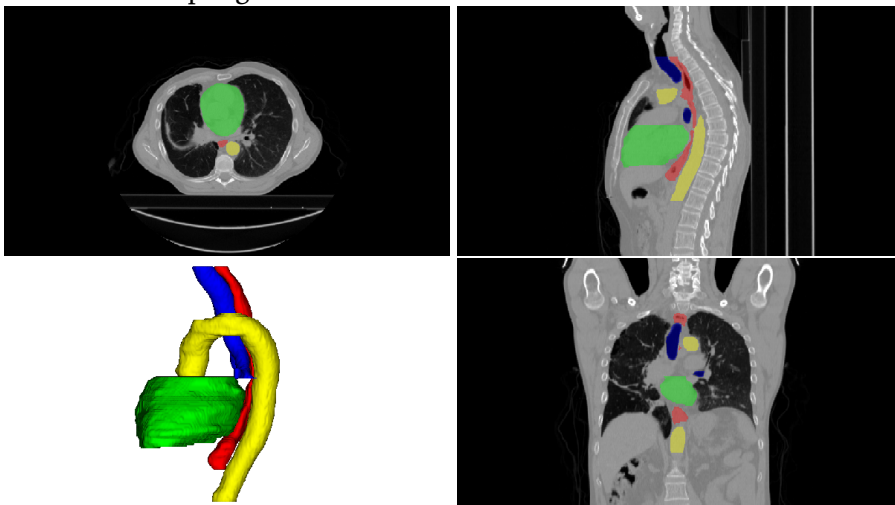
Representative chest CT image of the SegTHOR challenge with 3D view of risk structures.
